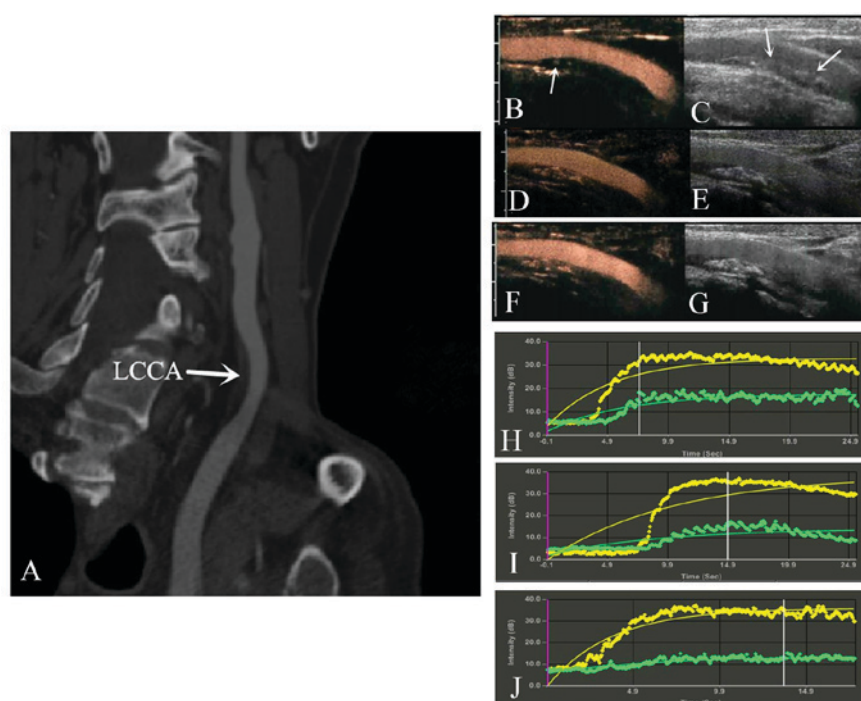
(A-J) Computed tomographic angiography analysis of the left common carotid artery. (A) A large soft plaque was indicated in the left common carotid artery (white arrow). (B) View following injection of contrast agent: The contrast agent entered into the plaque (white arrow) and (H) the time-signal intensity curves analysis revealed enhanced intensity in the plaque and lumen. (C) Longitudinal plane without contrast agent revealed a soft plaque in the CCA (white arrow). (D and E) Following 1 year of atorvastatin treatment, the plaque was enhanced without contrast agent and plaque neovascularization of CCA was reduced. (I) The time-signal intensity curves analysis revealed the arrive time which contrast agent entered into the plaque prolong and the peak intensity reduced slightly than before. (F and G) Following 2 years of atorvastatin treatment, the plaque was extensively enhanced without contrast agent and plaque neovascularization of CCA was reduced. (J) The time-signal intensity curves analysis revealed the arrive time which contrast agent entered into the plaque further prolong and the peak intensity reduced significantly. The lumen of the CCA was indicated by the yellow curve and plaque was indicated by the green curve in all time-signal intensity curves. CCA, common carotid artery; LCCA, left common carotid artery.
